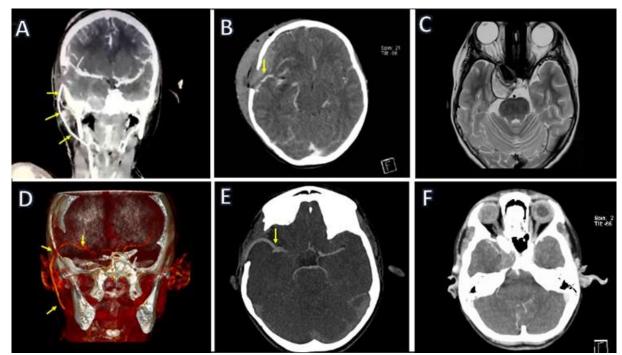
Postoperative images of 2 months (A-C) and 6 months (D-F) after surgery. A and D) Coronal view shows a patent bypass (yellow arrows). B and E) CTA in axial view. The MCA's bypass (arrow) and branches are seen without evidence of low-density areas. C and F) Pre and postop (6 months) images of the aneurysm. The mass effect is reduced with improvement of the cavernous sinus symptomatology.
